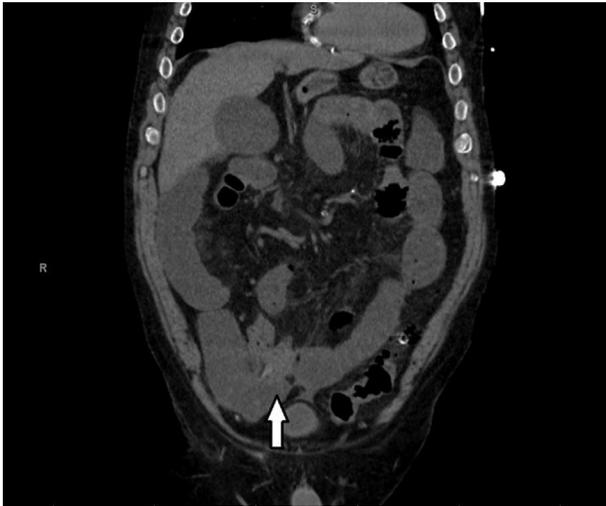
CT scan (coronal view) of the abdomen demonstrating terminal ileum thickening with upstream small bowel dilatation.
